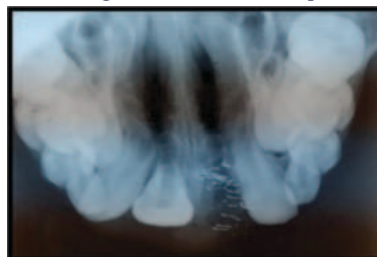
Occlusal Radiograph Confirming Displacement Without Root Fracture
